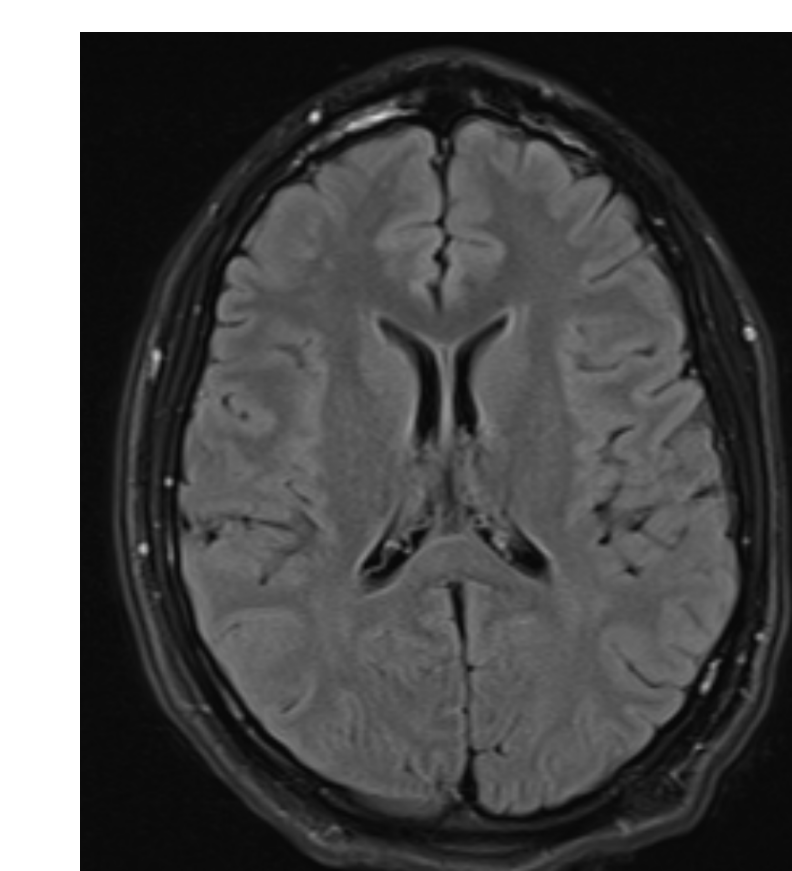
Axial flare sequence of repeat MRI brain 4 weeks later showing complete resolution of the splenial lesion.
